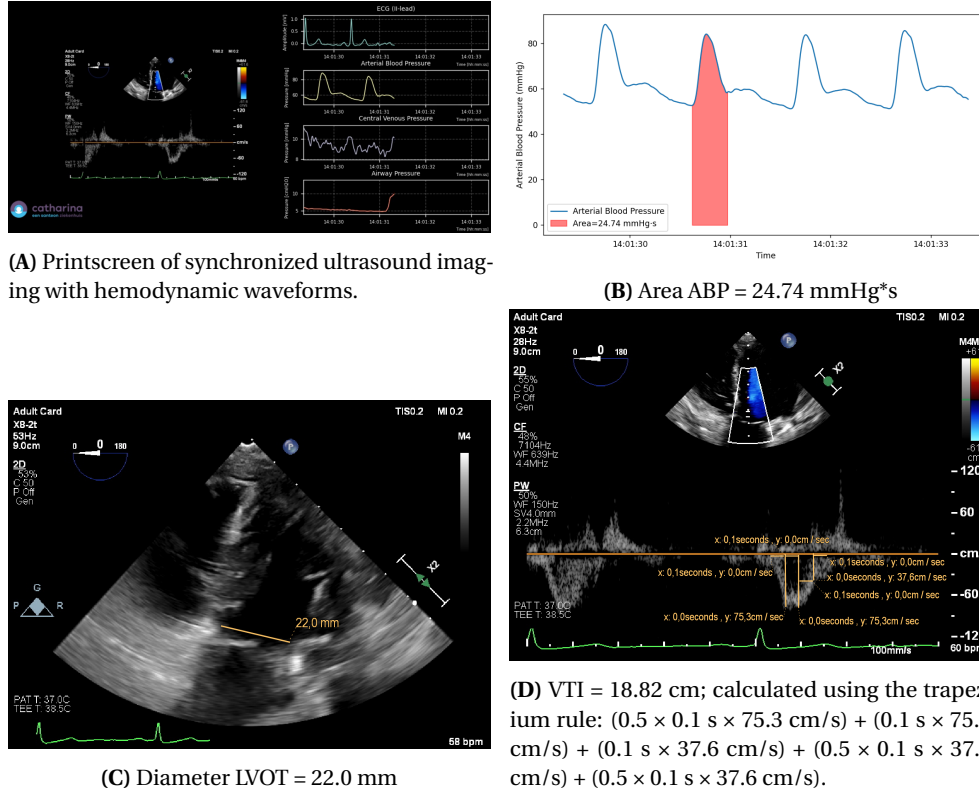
Usecase with (A) synchronized ultrasound imaging and hemodynamic waveforms from which the second heartbeat is used for calibration; (B) the area under the Arterial Blood Pressure (ABP) curve; (C) the measurement of the diameter of the Left Ventricular Outflow Tract (LVOT); (D) the calculation of the Velocity Time Integral (VTI) from Pulse Wave Doppler.
